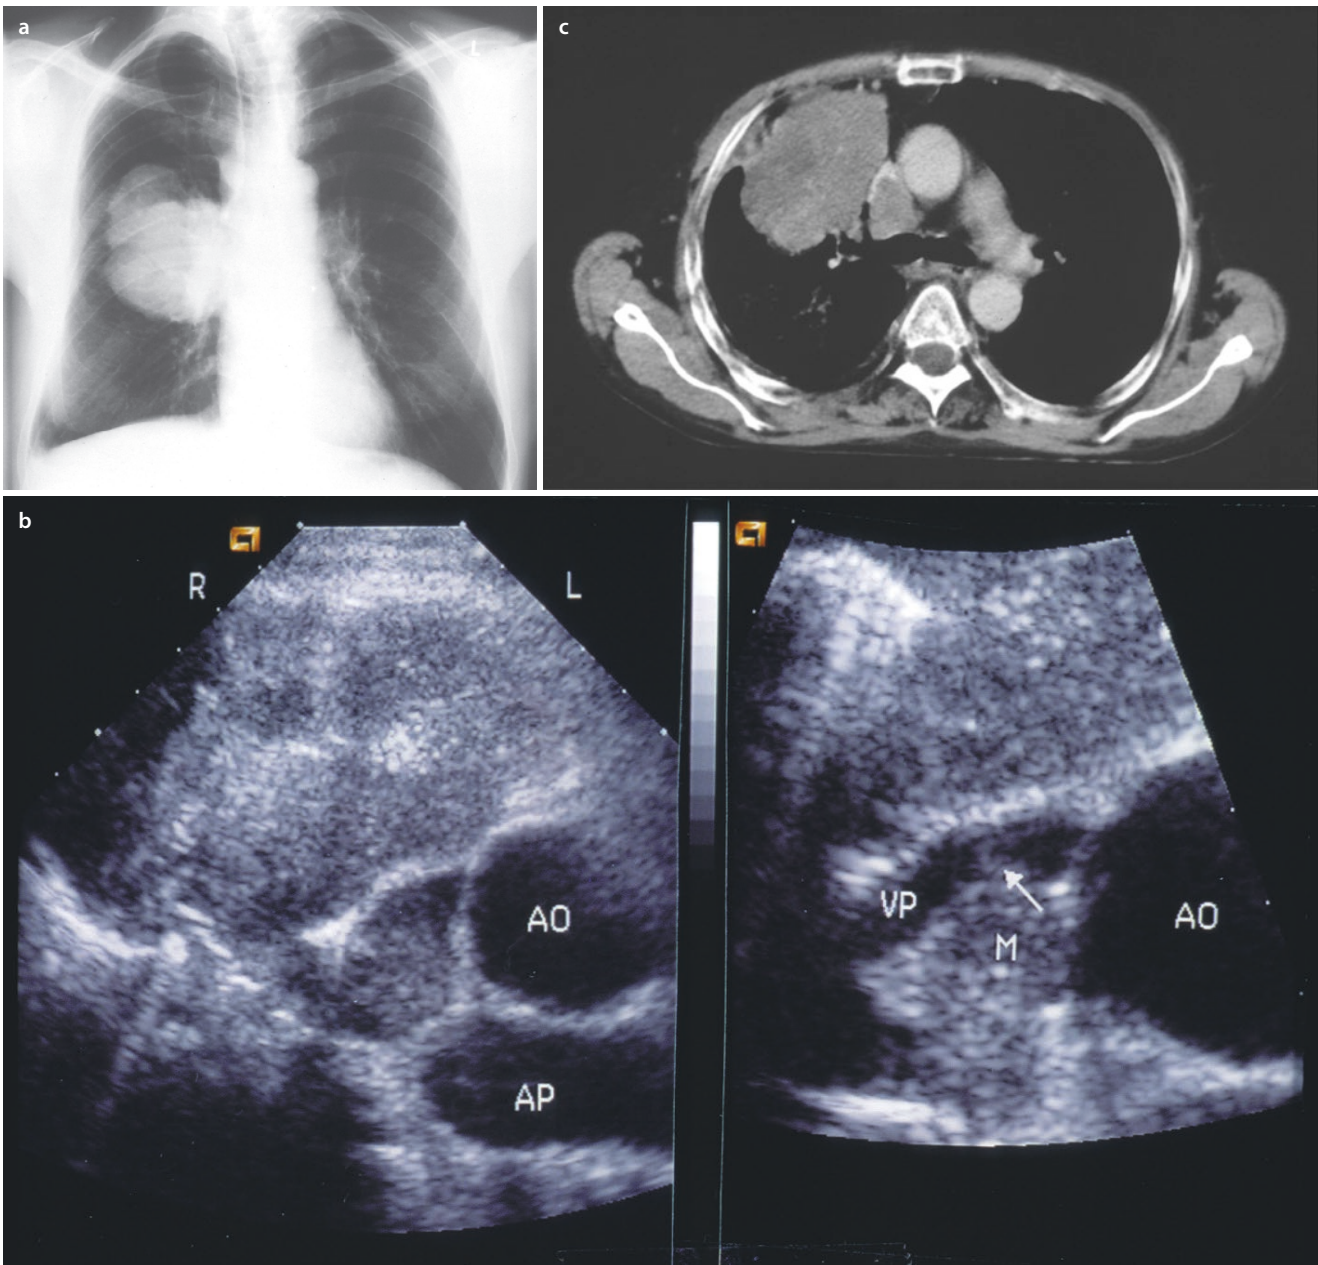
A 49-year-old man with a bronchial carcinoma. a Chest X-ray: central space-occupying mass in the right hilum. b Sonography: right-ventral intercostal echo transmission shows a hypoechoic transformation. The atelectatic lung tissue cannot be demarcated from
